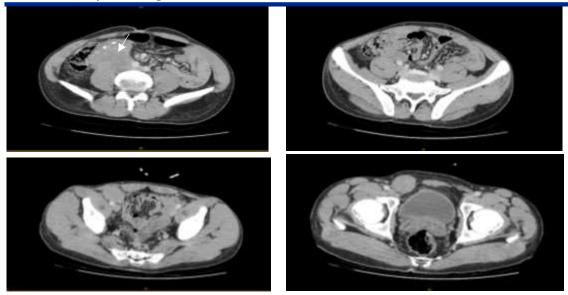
INITIAL CT SCAN.
